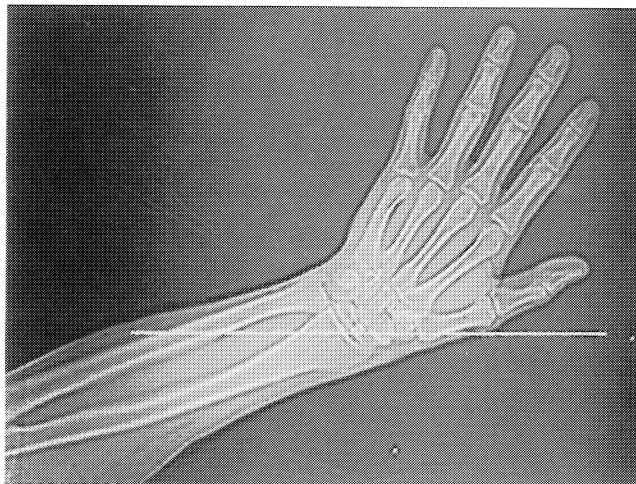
Scout image from a CT study showing correct position of the wrist for the sagittal long-axis study.
